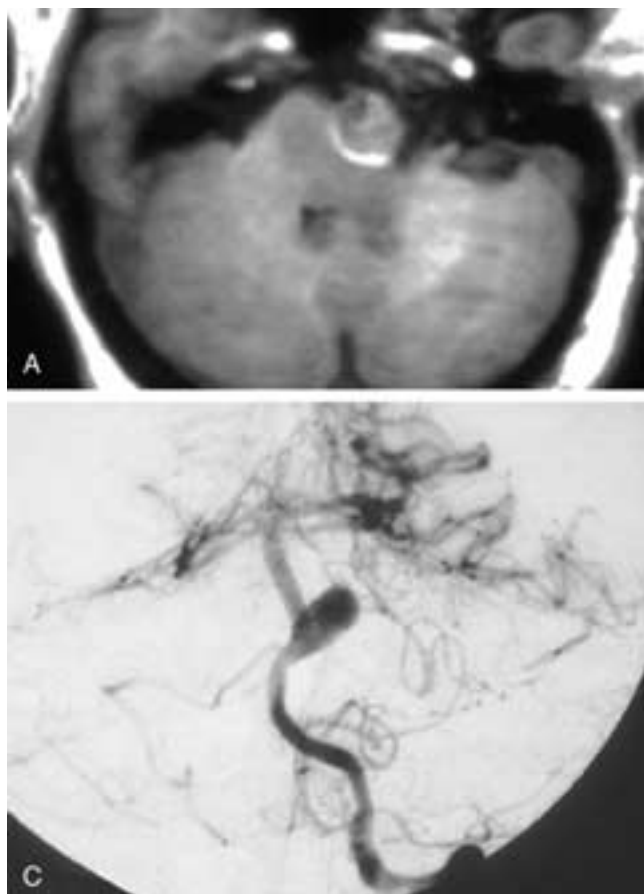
Giant AICA aneurysm. A, T1-weighted image. Large aneurysm with mixed signal from turbulent flow in the vortex. Note the mural thrombus, seen as a layer of high signal clot. B, T2-weighted image. Well-demarcated, round, hypointense mass with surrounding edema. C, Selective vertebral angiogram. Broad-necked giant aneurysm of the AICA basilar artery junction.
